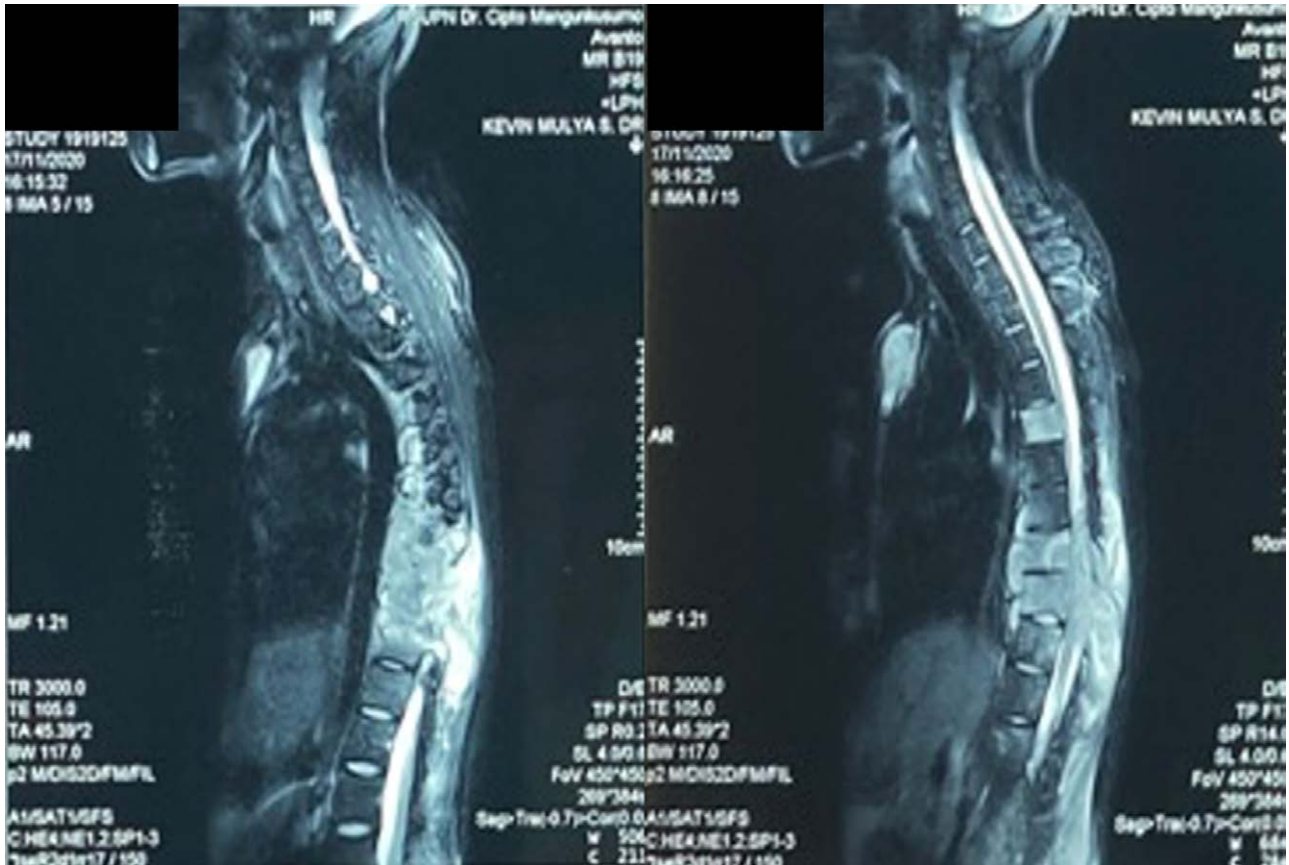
Preoperative clinical pictures and spine MRI with apparent mass on the sixth to 10th thoracic level in the midline.
